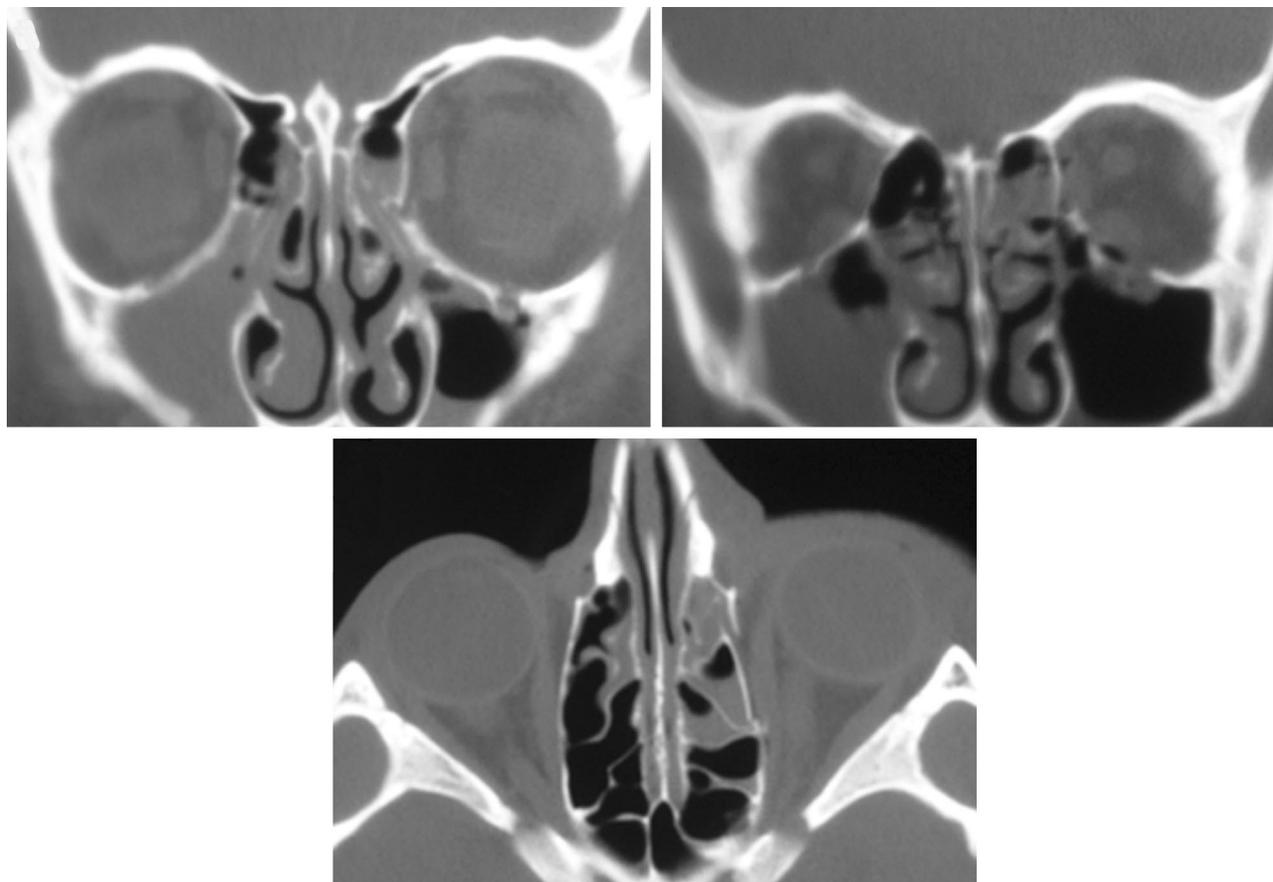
CT of the same patient as in Figure 2, showing trap door type fractures of the medial wall and floor of the left orbit with entrapped tissue.
